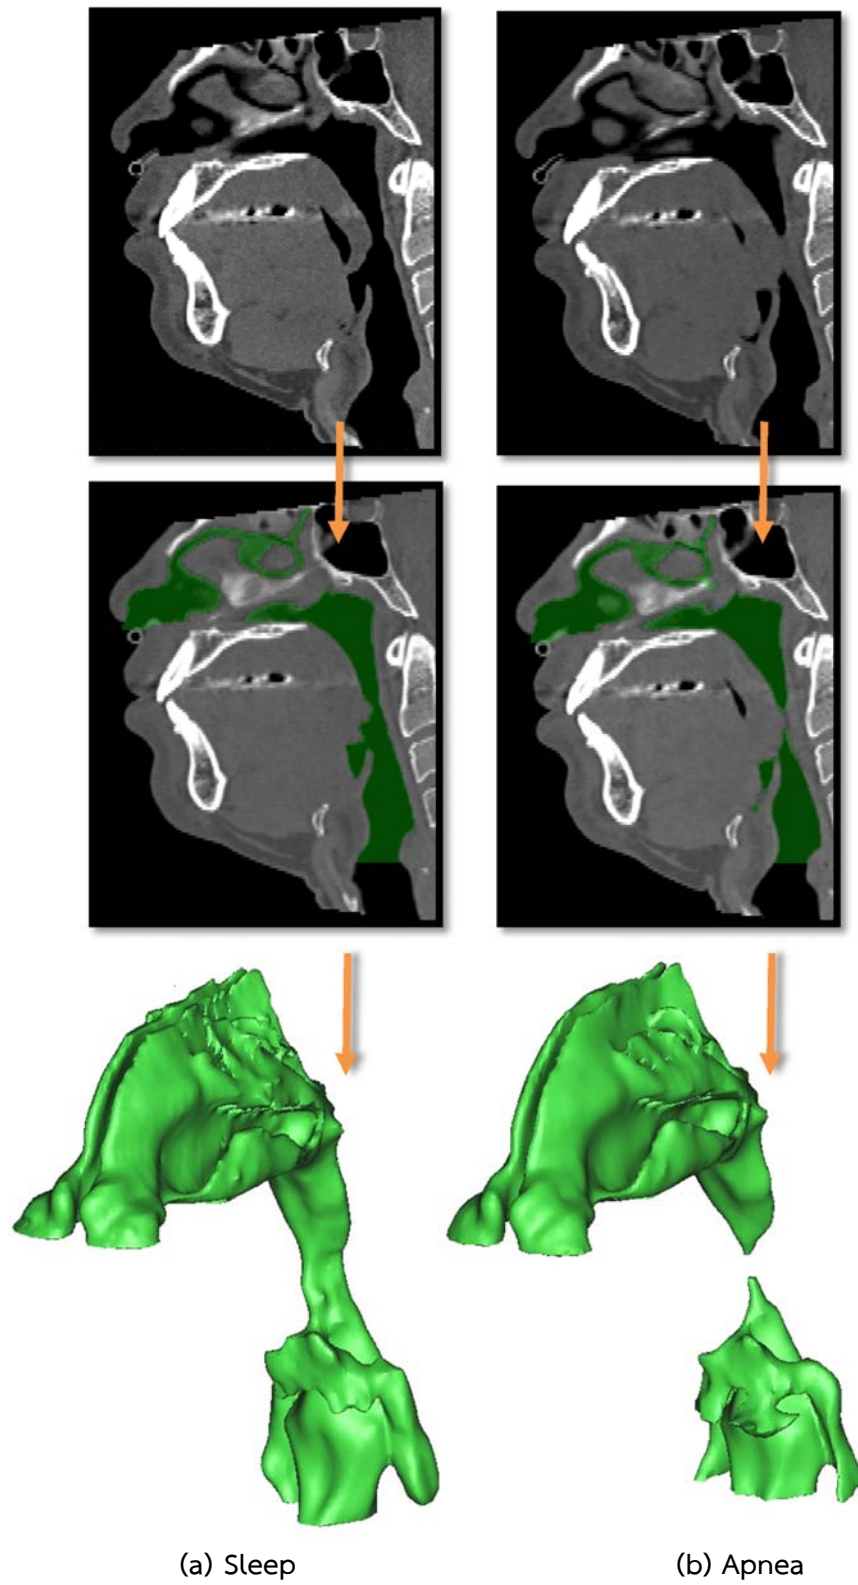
Three-dimensional airway geometry of patient who having OSA reconstructed from CT images during (a) sleep and (b) apnea
